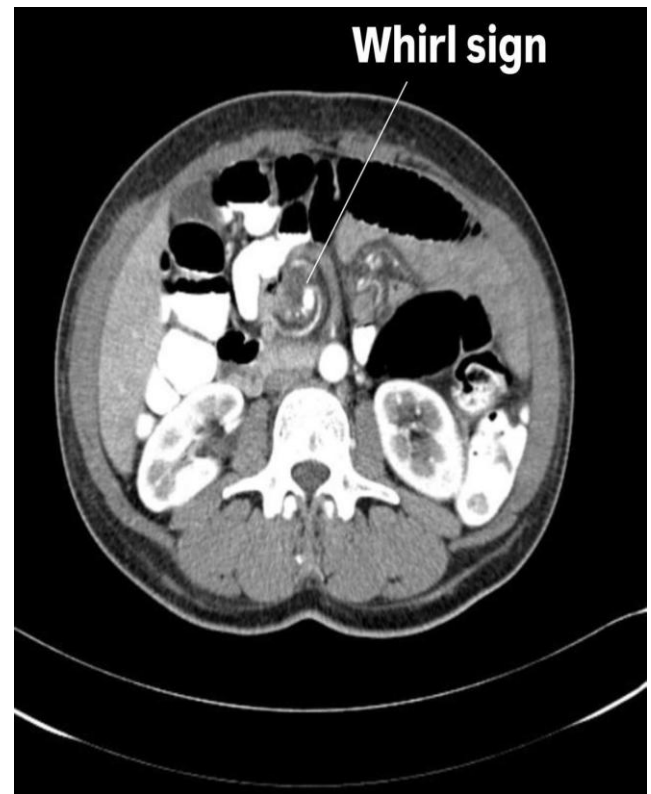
CT demonstrating the characteristic “WHIRL SIGN”
